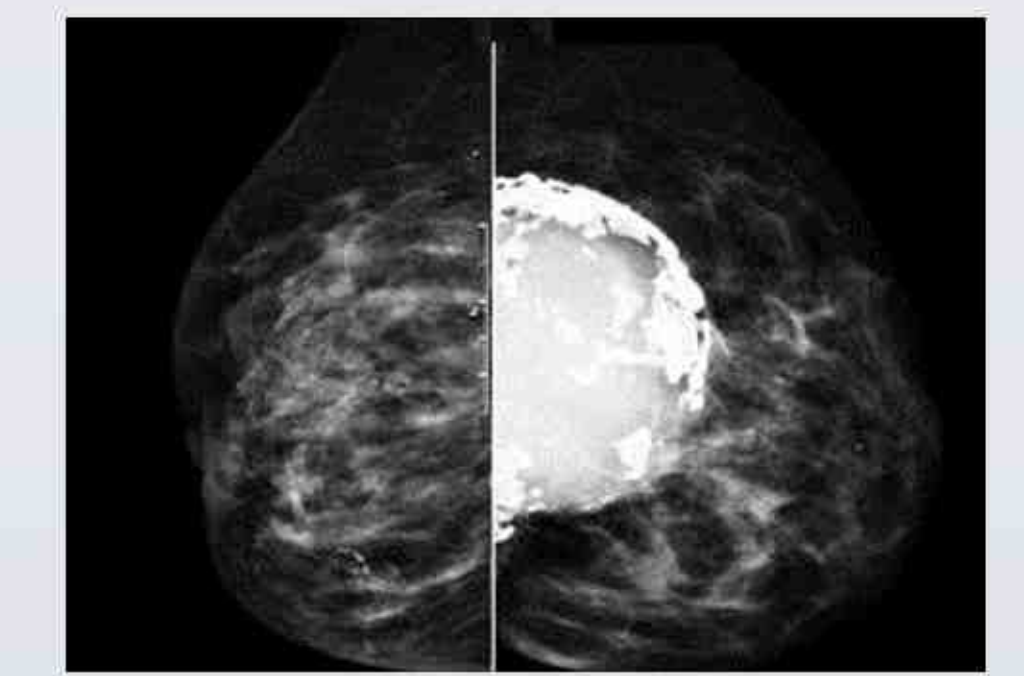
CT and mammo in a patient with scleroderma shows coarse dystrophic calcification within the breasts.
